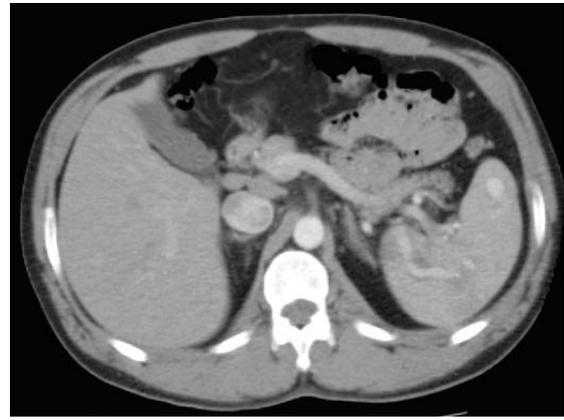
Patient developed a chronic nonunion of one of the rib fractures, which was still painful, and presented for evaluation of persistent left sided pain approximately 2 months following the initial accident. An abdominal CT scan demonstrates the development of a contained splenic pseudoaneurysm with arteriovenous fistula.
